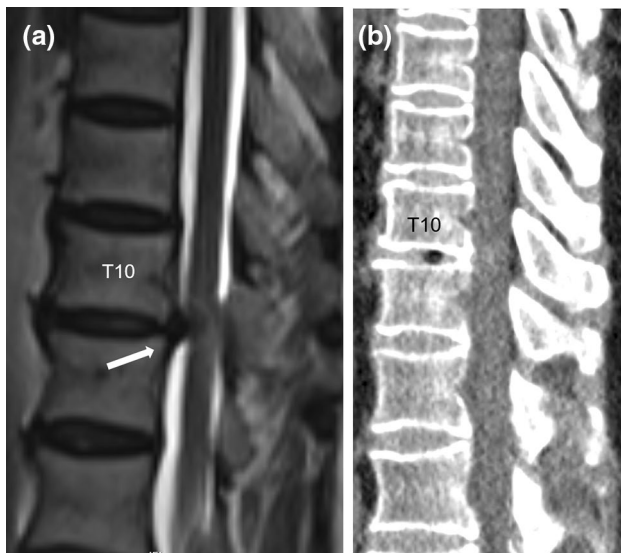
Sagittal magnetic resonance imaging (MRI) scans and computed tomography (CT) of the thoracic spine demonstrating TDM caused by TDH. 1(a) A typical T2W MRI image of a patient with TDH spinal compression and T2-hyperintensity at the T10-11 disk level. The white arrow indicates the herniated disk. 1(b) CT showed vacuum phenomena involving the T10-11 intervertebral disks, without ossification of the annulus fibrosus or posterior longitudinal ligament, and no calcification of the nucleus pulposus
